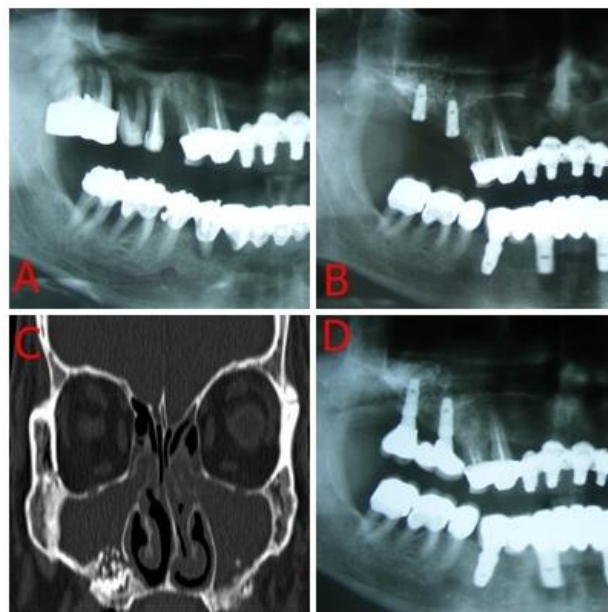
A. Severe periodontal disease around teeth 15,16,17 that present class III mobility, B. Dental extraction, lateral sinus lifting, post extraction dental implants 15,16,17; C. CT scan shows partial extrusion of the graft into the sinus and inflammation around the graft; D. Panoramic scan 1 year after endoscopic treatment
